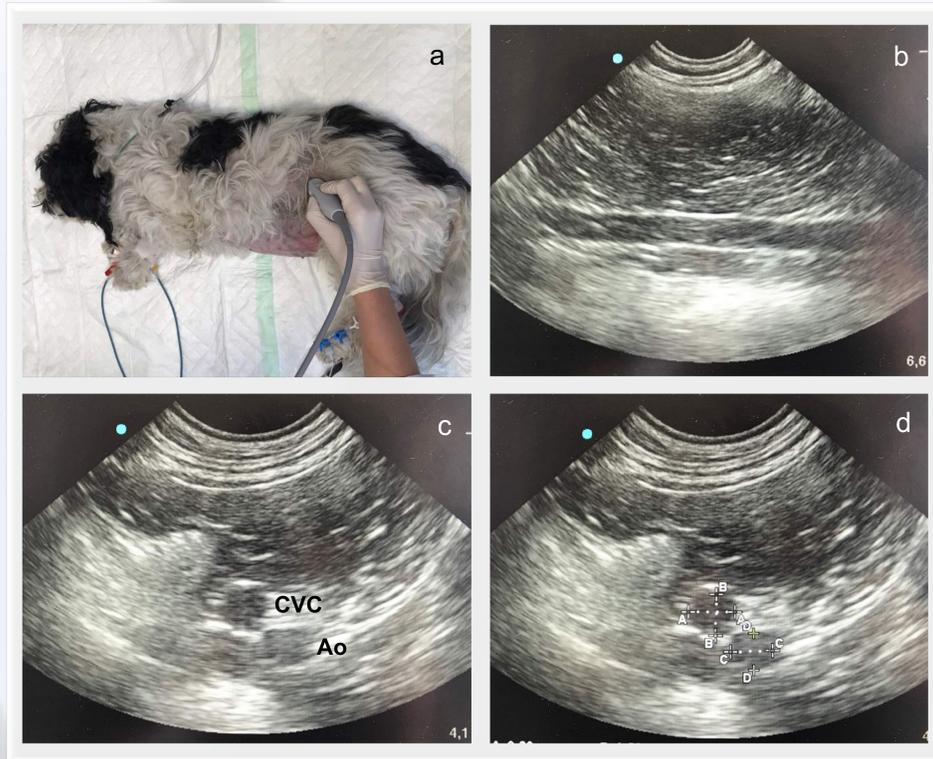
Ultrasonographic protocol
